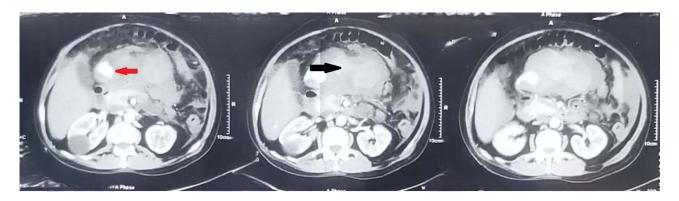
Figure I CT angiography of the abdomen and pelvis (axial view) showing a 14.3×8.8 cm hematoma observed in the paraumbilical region (black arrow) containing a 3.4×2.2 cm arterial aneurysm connected to the gastroduodenal artery (red arrow), with surrounding edematous changes. These findings are suggestive of a large, thrombosed GDA aneurysm.
